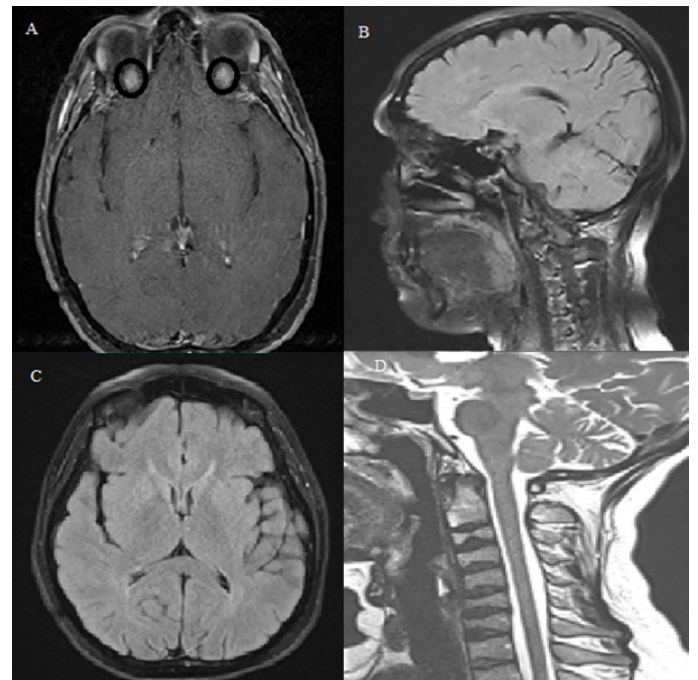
A: The patient's T2 sequence contrast-enhanced orbital MRI imaging shows bilateral contrast uptake in the optic nerve in the transverse section, suggesting the presence of optic neuritis with some degree of uncertainty indicated by the question mark.
